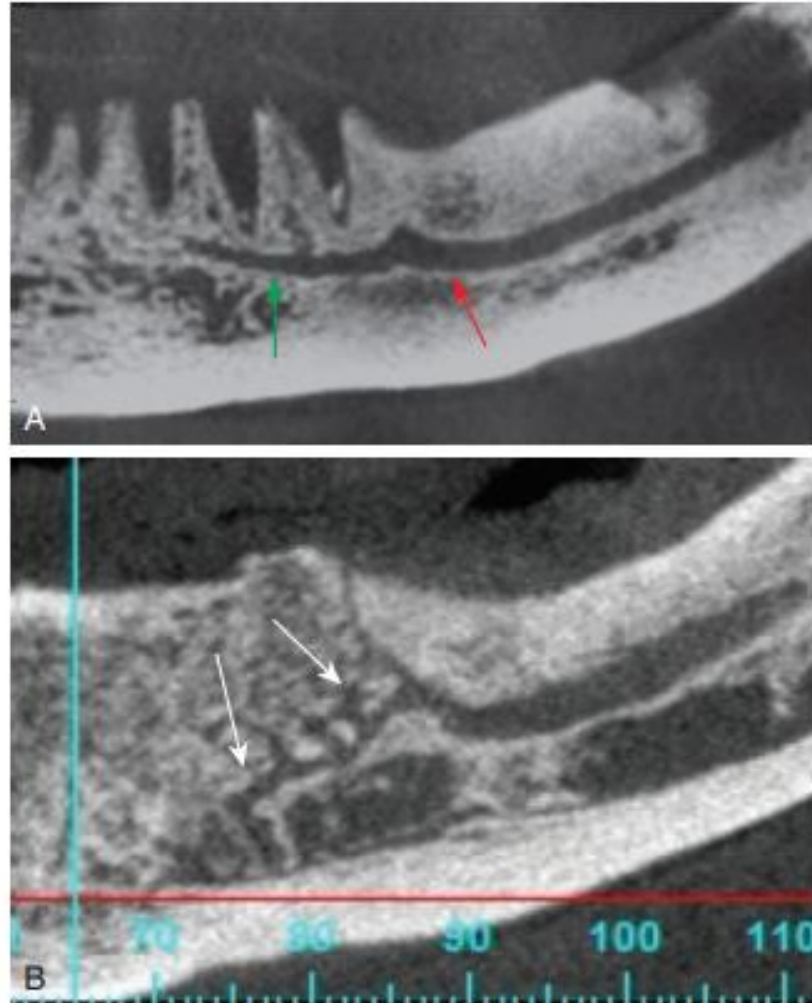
The incisive canal is a continuation of the inferior alveolar canal, which contains the incisive nerve, which innervates the mandibular anterior teeth (red shows the inferior alveolar canal; green shows the incisive canal). (A) CBCT image showing incisal canal extension from mandibular canal, and (B) CBCT panoramic image showing branching of incisive canal (arrows).
